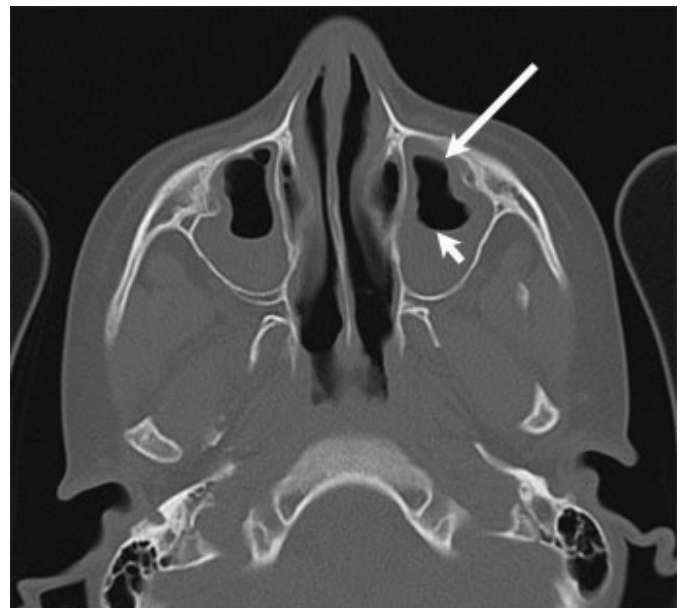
CT demonstrates mucosal thickening (long arrow), and an air-fluid level (short arrow), findings seen in sinusitis.
